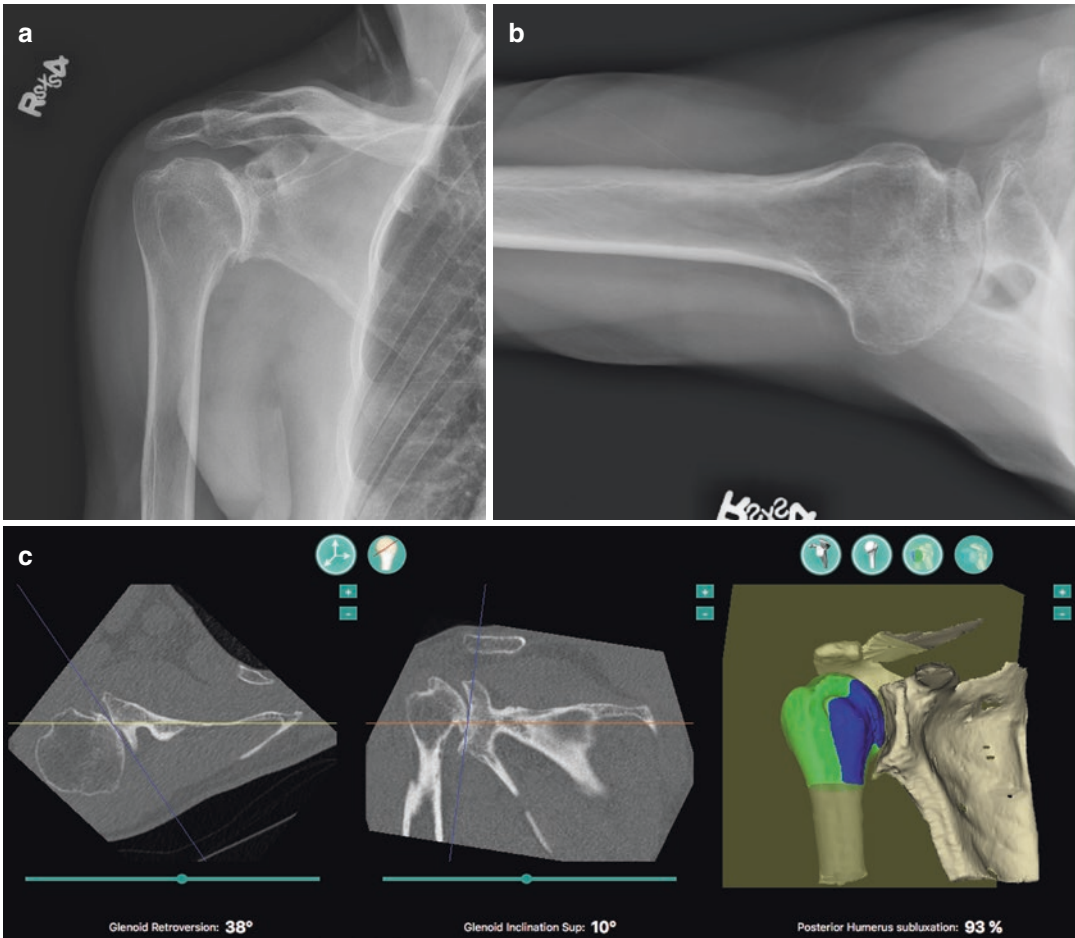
B2 glenoid managed with posterior glenoid bone graft. (a) True AP view of the right shoulder of a 57-year-old male with advanced glenohumeral osteoarthritis. (b) Axillary view of the same shoulder demonstrating severe posterior humeral head subluxation and a biconcave glenoid (B2 deformity). (c) Three-dimensional software analysis of a CT scan of the same shoulder. Glenoid retroversion measures 38°. (d) Intraoperative picture of the same shoulder. Placement of an autologous
